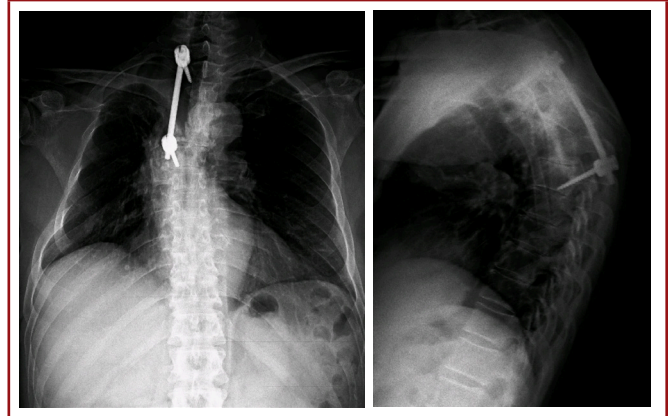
N.B., 61 years old man with lung cancer. The postoperative CT showed T5 compression fracture that have more resected and osteoporotic vertebra corpus. There is no neurological problem or pain related the kyphosis.
